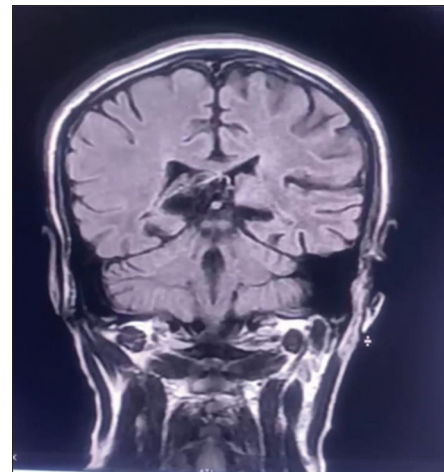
Magnetic resonance imaging brain showing the ventriculoperitoneal shunt *in situ* with its tip in the left lateral ventricle and normal third, fourth and lateral ventricular spaces bilaterally
